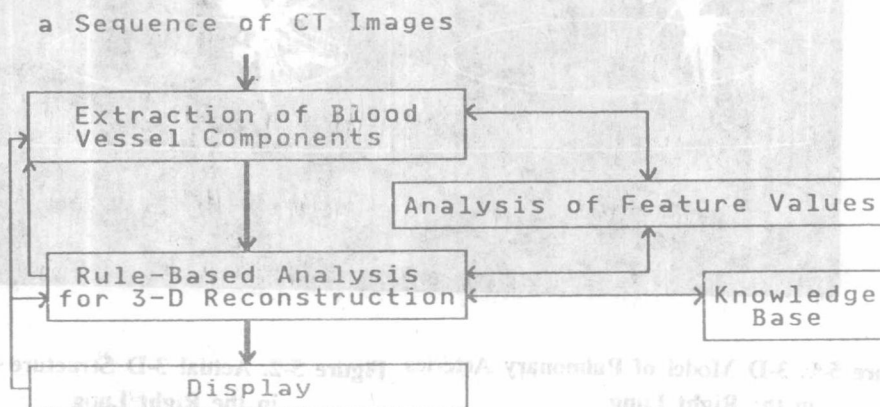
Reconstruction of Pulmonary Blood Vessel Structure from CT images
